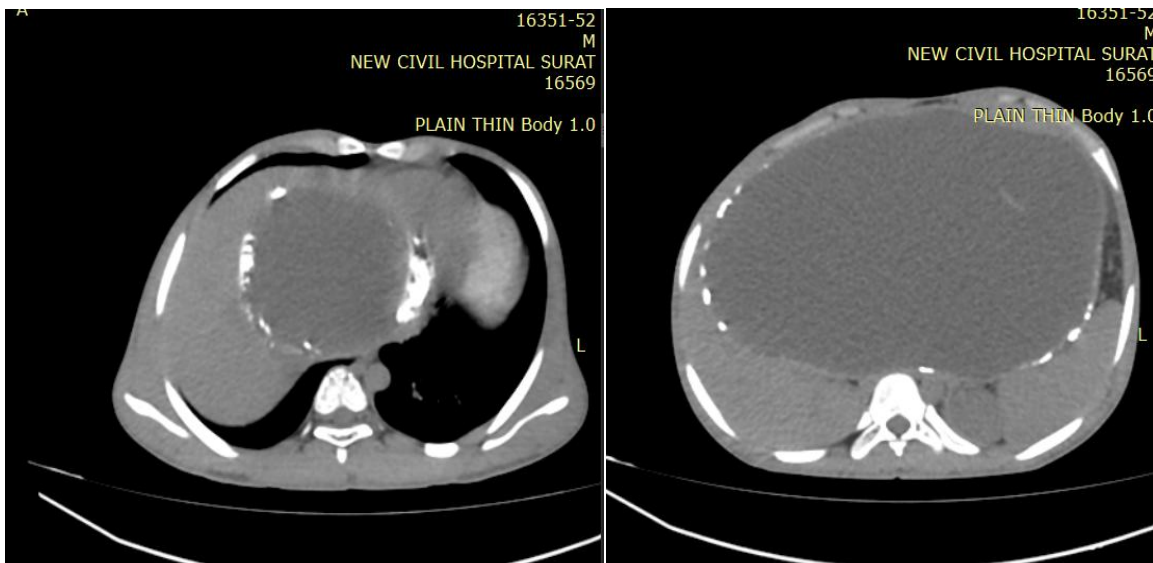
Axial plain CT abdomen shows a large heterogeneous mass with cystic, calcified, soft tissue components, and bony elements; with multiple chunks of calcification within its entire wall.
